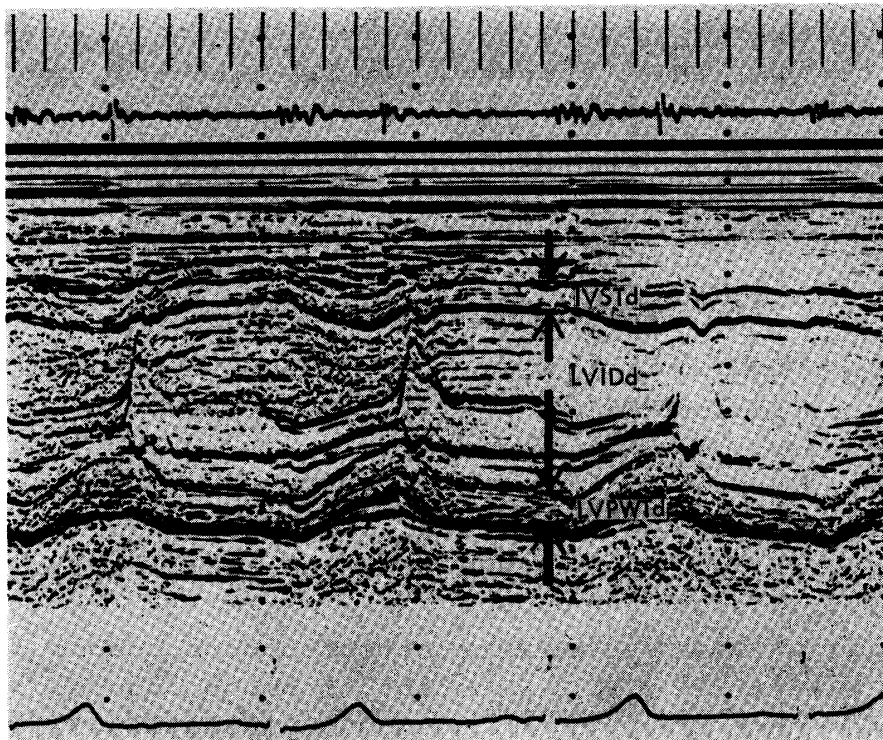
M-mode echocardiogram recorded. Landmarks for measurement are displayed.
